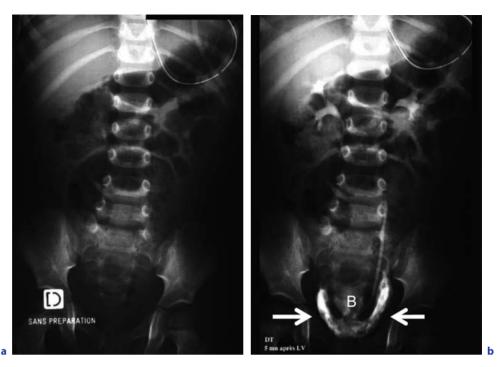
Bladder neck disruption in a young boy who underwent blunt abdominal trauma. Intravenous urography. Plain film (a) showed traumatic widening of the pubic symphysis. (b) As soon as 5 min, the faintly opacified urinary bladder (*B*) appears elevated by an infravesical leak (*arrows*)
